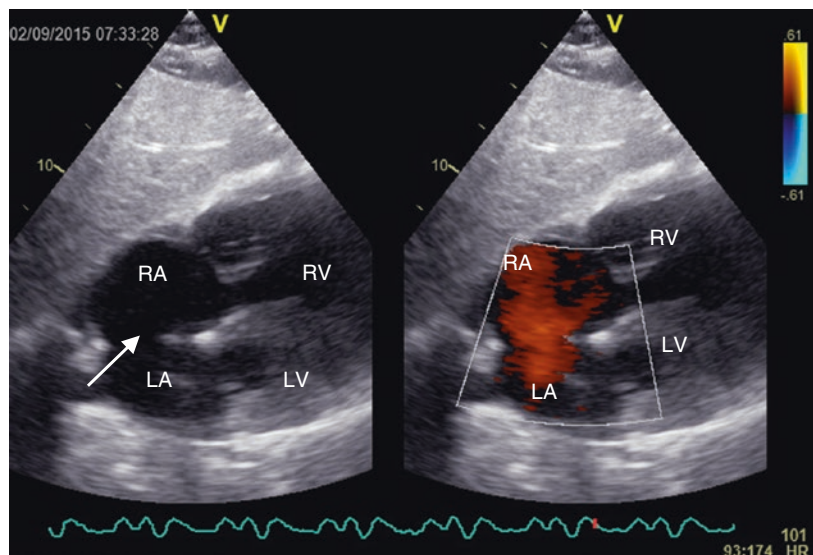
Left: Two-dimensional echocardiogram, apical subcostal four-chamber view. There is a large ostium secundum ASD (Arrow). Right: Color Doppler evaluation: the left-to-right shunt is seen through the ASD (red color). LA left atrium, RA right atrium, RV right ventricle
